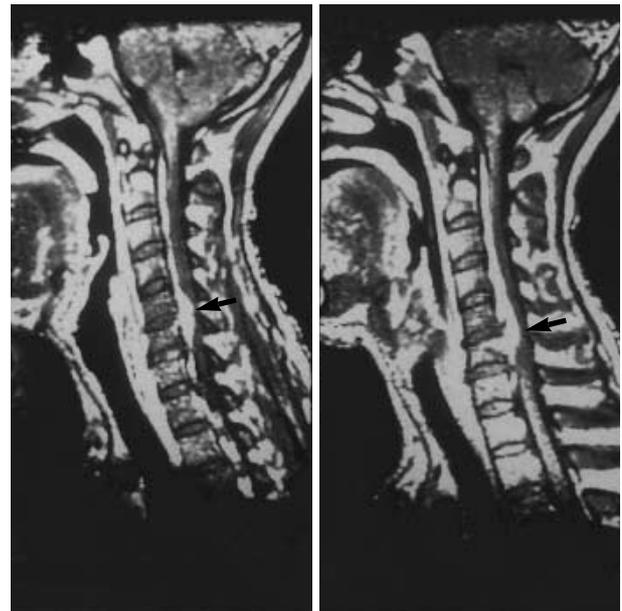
Cervical sagittal magnetic resonance imaging (MRI) with Gadolinium enhancement shows an enhanced epidural space occupying lesion located anteriorly to the cervical spinal cord, which extends from C1 to C7 with maximum thickness at C5-6 level (arrows).
